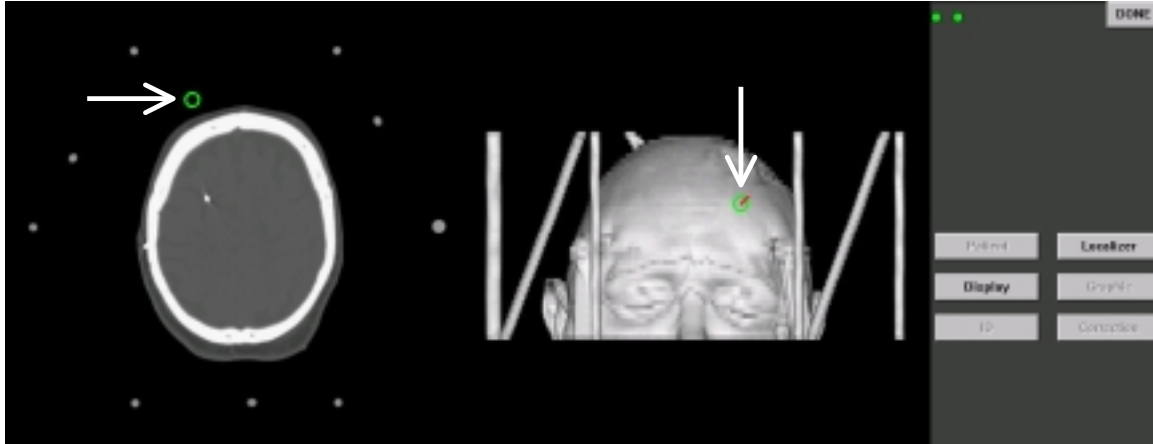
Sample screenshot of the Orion software system. On the left is one slice from a head CT image volume, while the right image is a volume rendering of the CT volume. The current surgical position of the probe is shown on each image by a circular cursor, indicated by the arrow.
